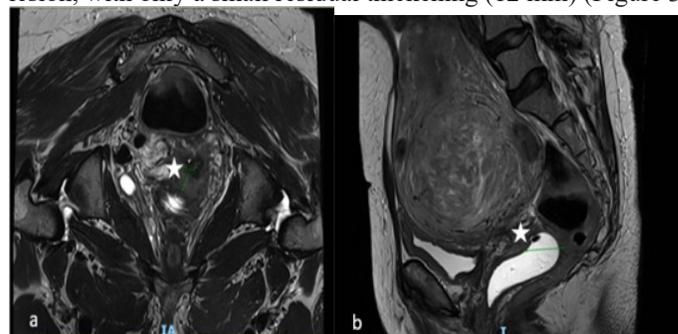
Axial T1-weighted (a) and sagittal T2-weighted (b) pelvic MRI after three months of antibiotic therapy shows only a small residual thickening (12 mm) (asterisks).
